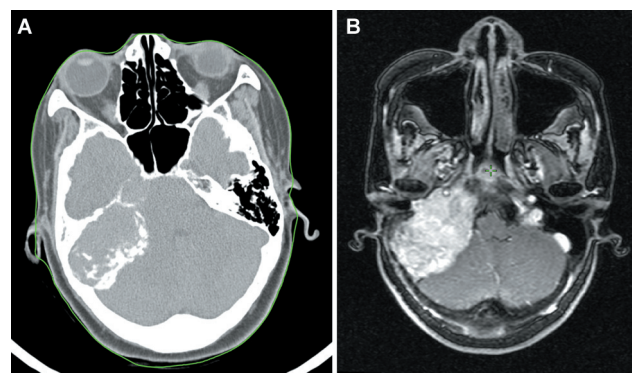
Axial section of CT (A) and T1-weighted MRI (B) image showing a large, hyperdense/hyperintense, expansile, multiloculated, osteolytic mass epicentered at the squamous and petrous part of the right temporal bone, compressing the adjacent brain parenchyma.
